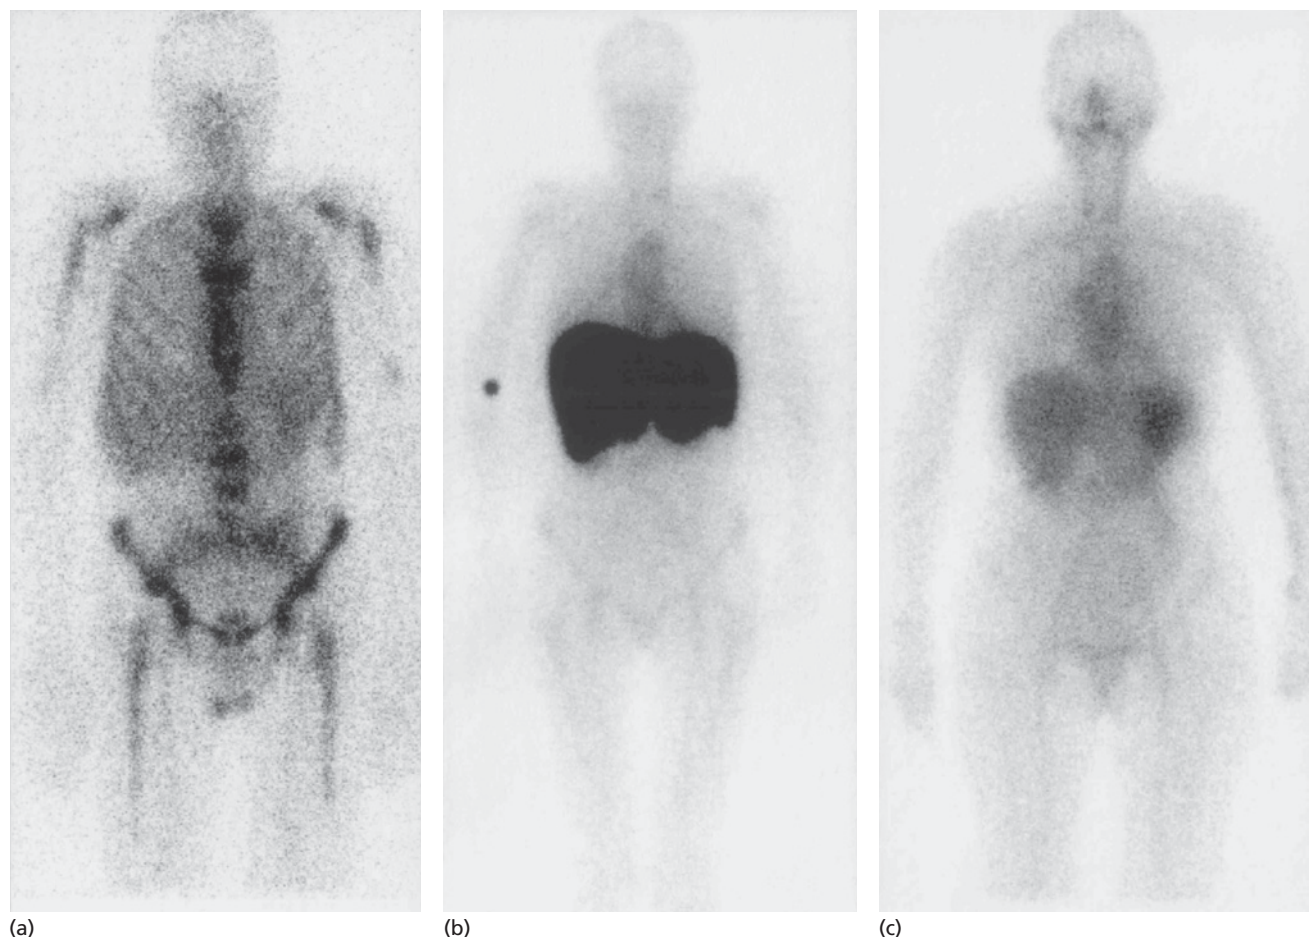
Radiolabelled ^{123}I -SAP whole-body scintigraphy, anterior images. (a) The tracer has localized virtually exclusively to amyloid deposits in the bones in this particular patient, a distribution that is almost pathognomonic for amyloid of AL type. (b, c) Serial scintigraphs in a 56-year-old woman with AL
